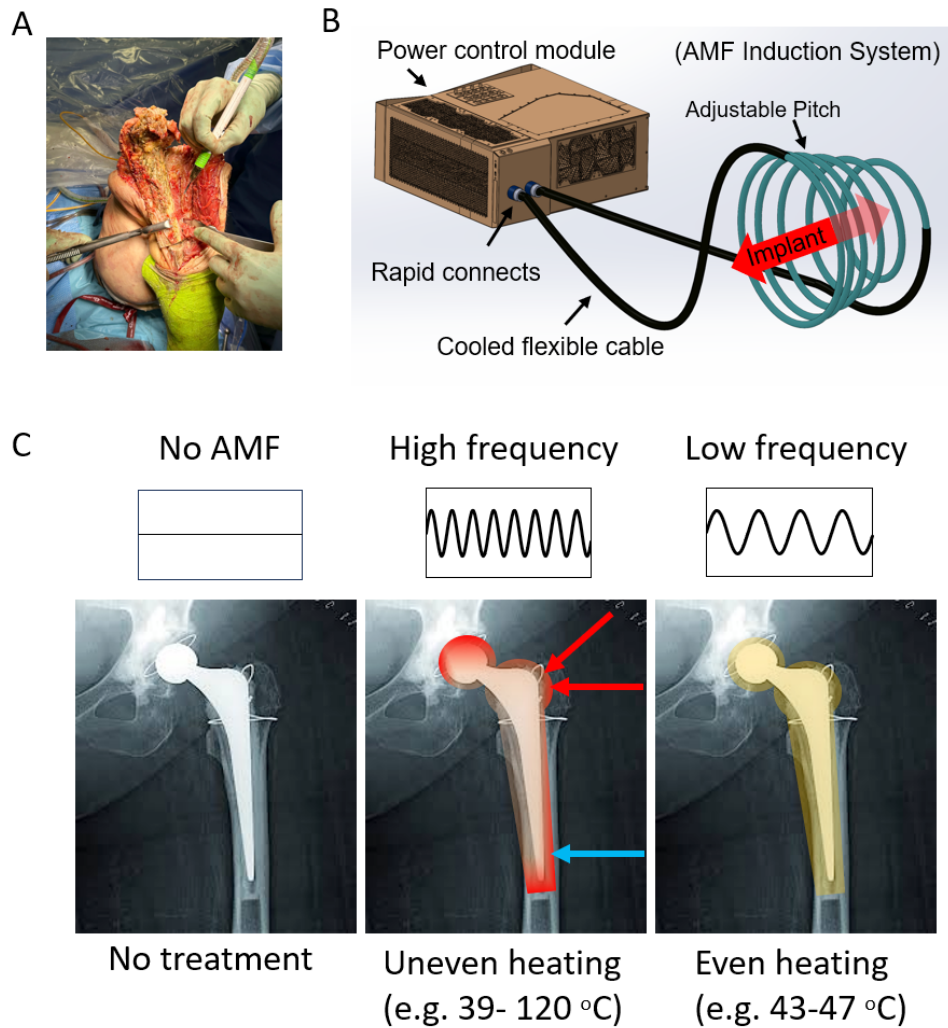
Revision of a necrotic implant. B) Alternating-Magnetic Field (AMF) system, further described in text. C) Artistic comparison of the effects of no AMF, a previously described high frequency 530 kHz AMF, and the newly developed ultra-low/low 1kHz-80kHz frequency which allows for uniform heating avoiding uneven heating on stress risers- Radiograph modified from Reilingh et al. [30], CC BY 4.0.
